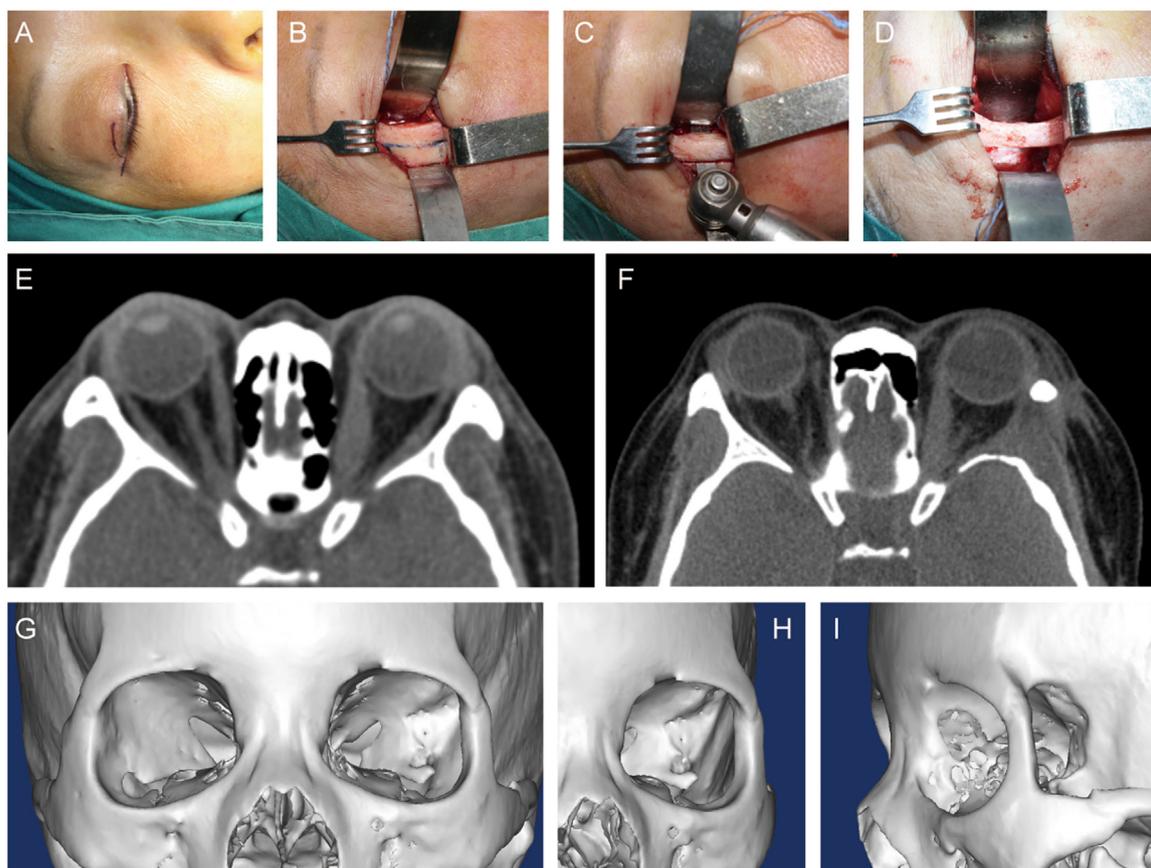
(A) Photograph showing the intraoperative landmarks for the incision along the double eyelid fold. (B) Photograph showing the L-shaped landmark of the osteotomy made in the lateral wall 5 mm posterior to the lateral rim. (C and D) Photographs showing the intact orbital rim and bony window following osteotomy. (E) Preoperative and (F) postoperative CT images of a patient who underwent left deep lateral wall orbital decompression with the rim-sparing technique. (G–I) Postoperative three-dimensional CT reconstruction; the left orbital rim was left intact.
